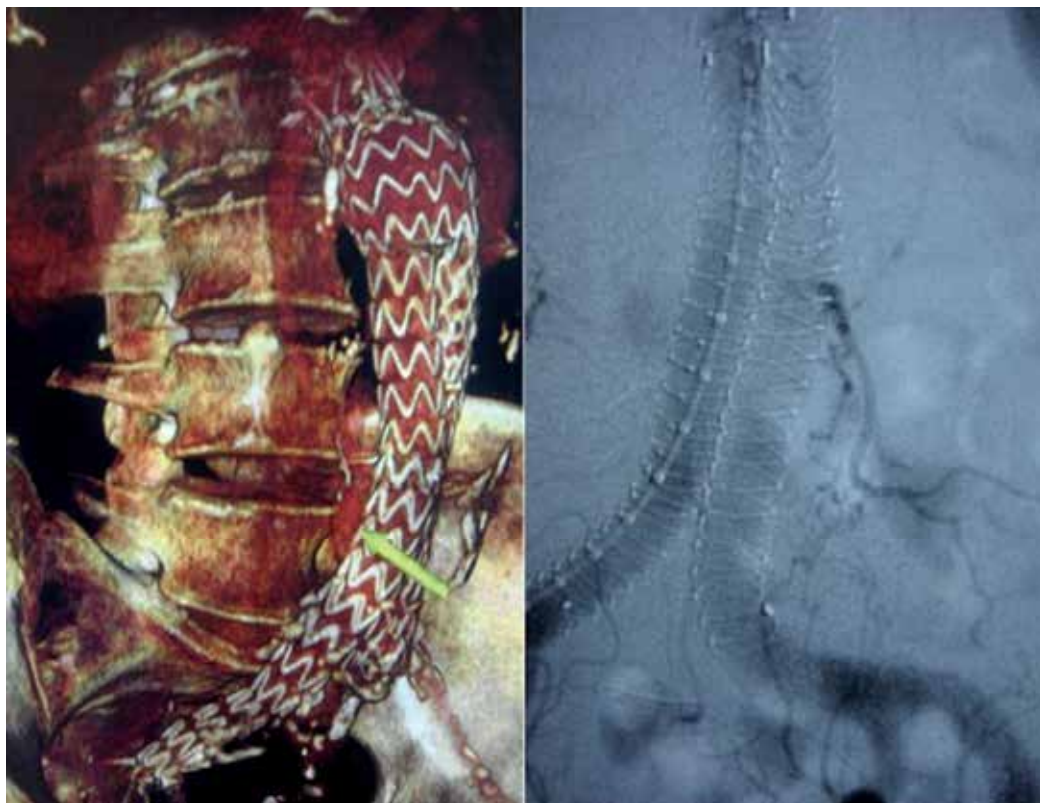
Left:* CT angiography with 3D reconstruction. Endurant bifurcated endoprosthesis (Medtronic Ave, St. Rosa, Cal) with a type II endoleak originated from the inferior mesenteric artery, yellow arrow. *Right:* Arteriography. Anaconda bifurcated endoprosthesis (Vascutek Inc., a Terumo Company, Renfrewshire, Scotland, UK) with a type II endoleak originated from a left lumbar artery.
